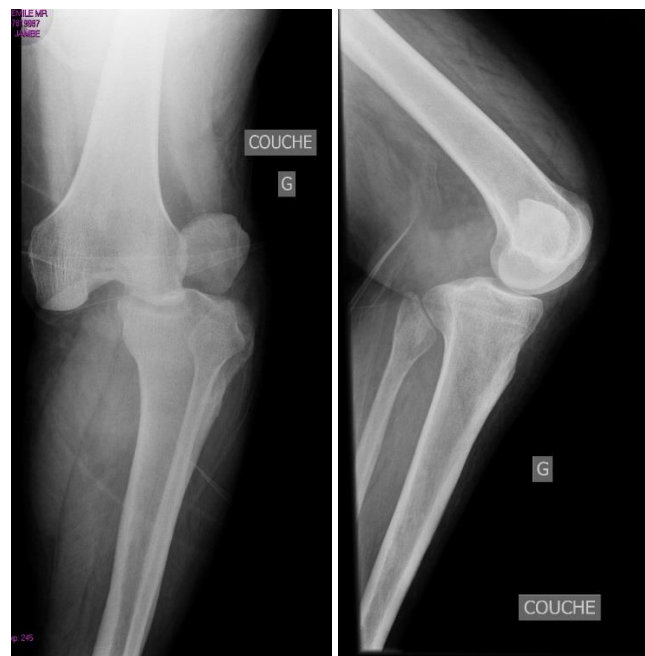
Anteroposterior and lateral radiographs of the left knee showing posterolateral knee dislocation without fractures
